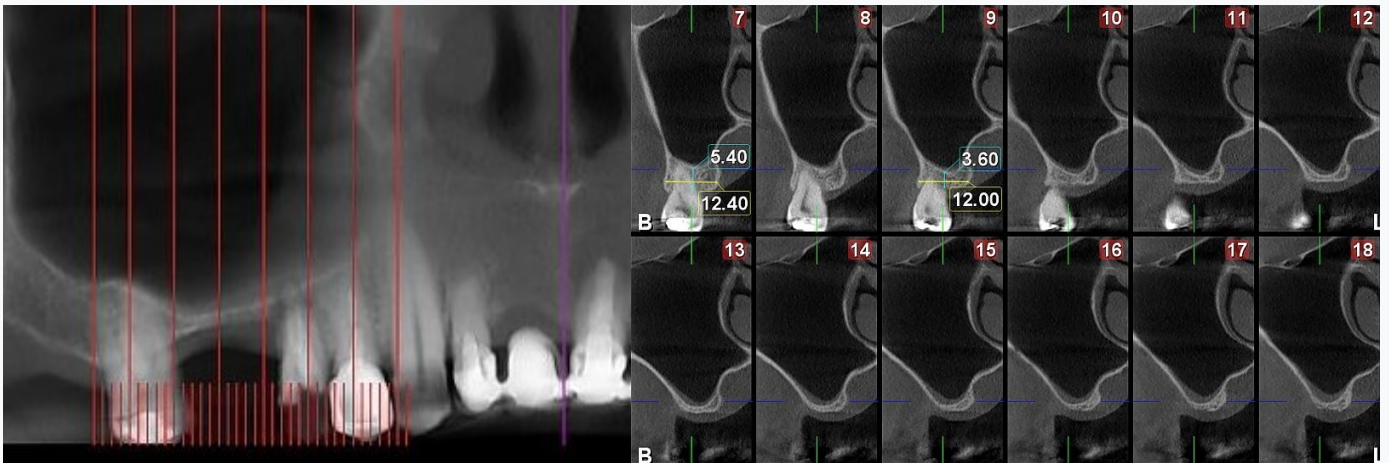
CBCT radiographs demonstrating minimal crestal bone in the posterior maxilla.
